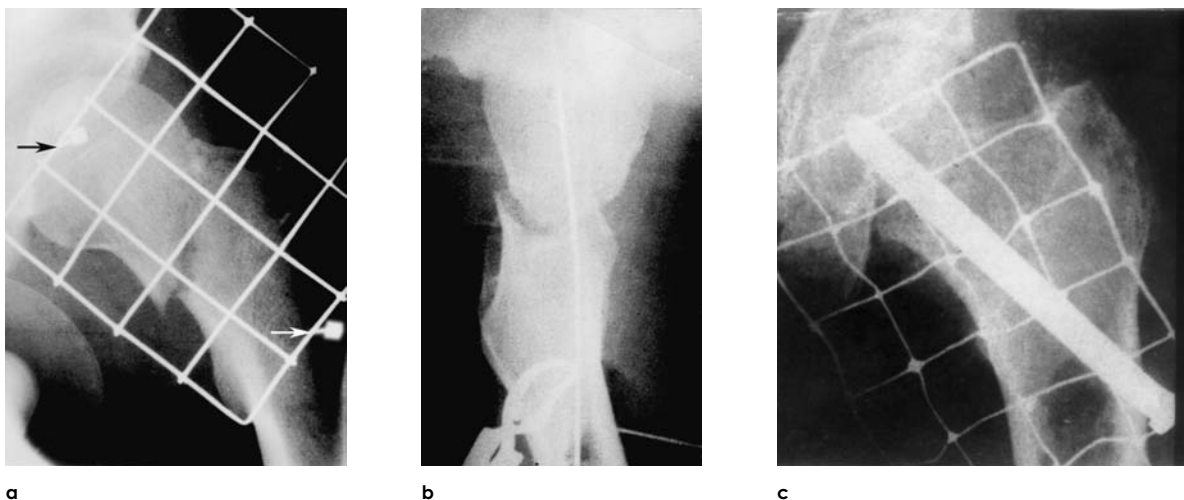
Radiographs of a femoral neck nailing taken from our archive.
